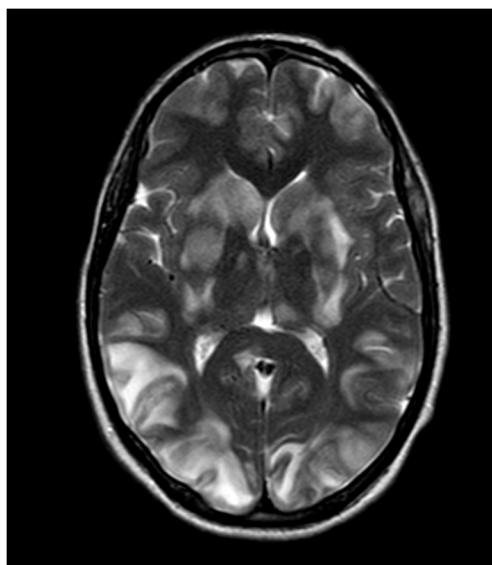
MRI BRAIN- T2 AXIAL
